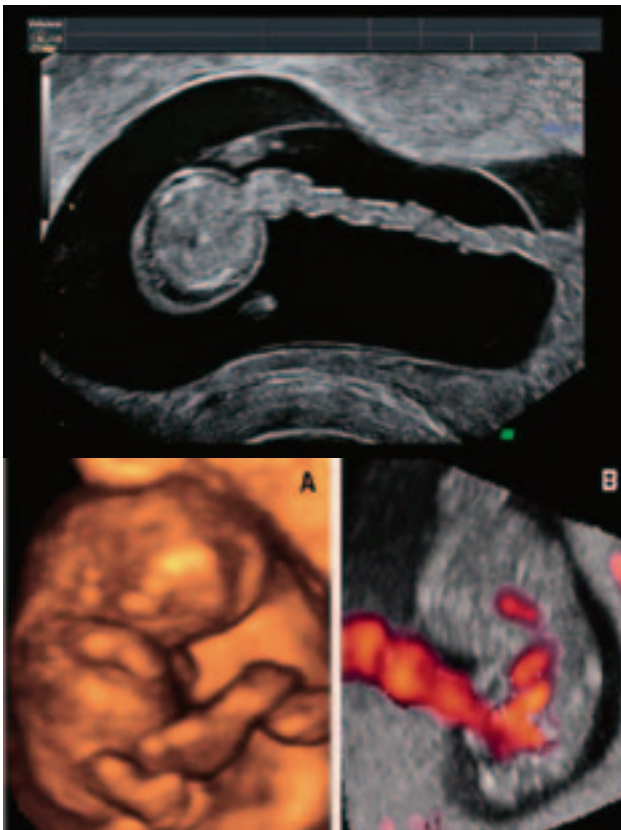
Visualisation of the umbilical cord and its vascularisation using 2D, 3D and 3D power Doppler technique.
